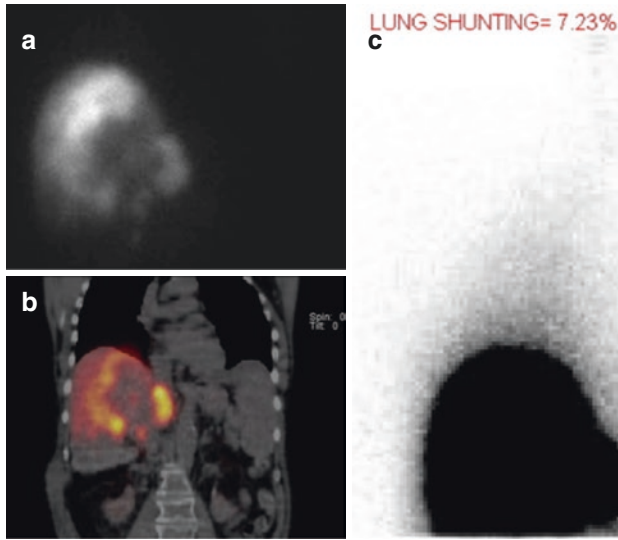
^{99m}Tc -labeled-MAA scintigraphy was performed in a 68-year-old man with intrahepatic cholangiocarcinoma. (a) Single photon emission computed tomography (SPECT) imaging performed by rotating a gamma camera around the patient, which demonstrates high uptake in the expected location of the liver. Region of photopenia in the left lobe of the liver corresponds to an area of central necrosis within a dominant mass. (b) SPECT radiotracer uptake superimposed on a low-dose attenuation correction CT demonstrates that the uptake corresponds to the liver without evidence of significant extrahepatic uptake. (c) Hepatopulmonary shunt fraction calculated based on planar scintigram demonstrates a lung shunt fraction of 7.23%. The patient was able to undergo successful treatment without radiation dose reduction
